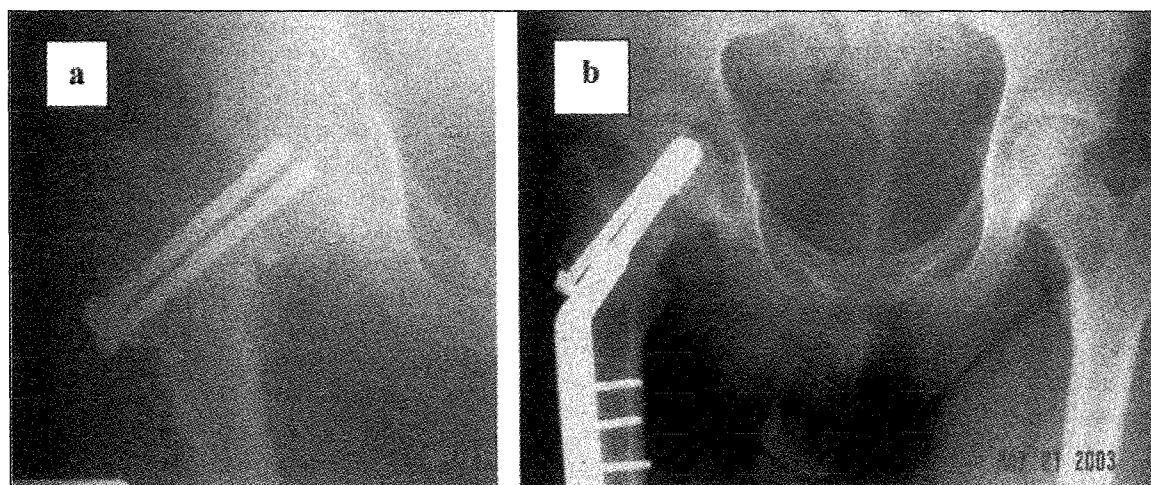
a - Radiograph of the affected hip showing the proximal fracture fragment in varus and the fracture was unreduced (indicated by screw pull-out without evidences of peri-implant bone resorption and implant bending). b - Post-revision radiograph showing better alignment of the proximal fragment and stabilization option using sliding compression screw and anti-rotation screw.
